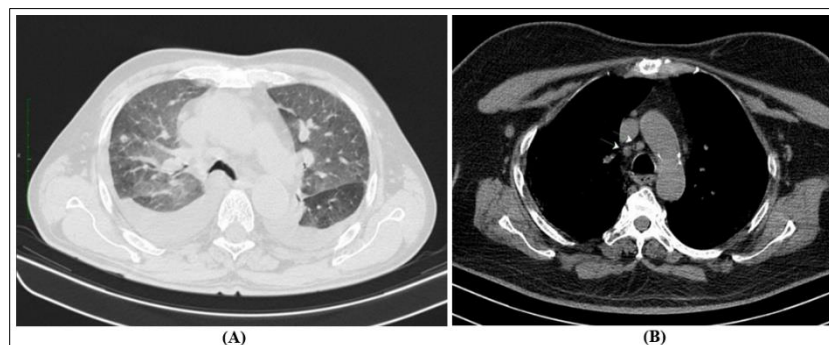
Image (A) Non contrast chest CT of 70-year-old RT-PCR positive male patient. Axial section at aortic root level showing diffuse ground glass opacities bilateral upper lobes. Bilateral moderate pleural effusion is seen along the bilateral posterior costal pleura. With a small nodular opacity measuring 4 mm in the right upper lobe. Image (B) Non contrast chest CT of 66-year-old RT-PCR positive male patient. Axial section at the level of arch of aorta in soft tissue window showing multiple sub centimetric mediastinal lymph nodes.
